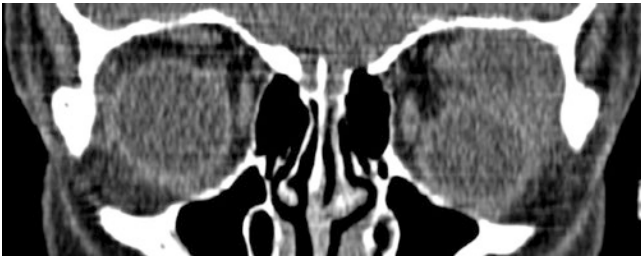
Left orbital rhabdomyosarcoma. Coronal reconstructed CT image demonstrates a soft-tissue mass superiorly within the left orbit, displacing the left globe inferiorly. The density of the mass is similar to the adjacent extraconal muscles
